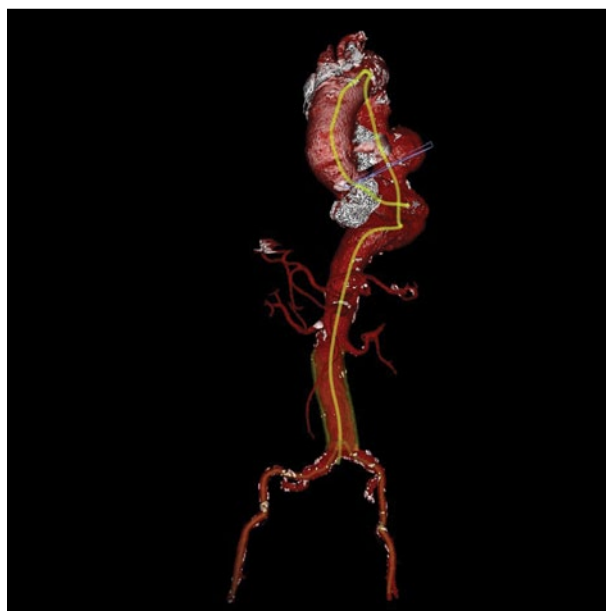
Preoperative CTA showing the tortuous course of the bilateral iliac arteries.
